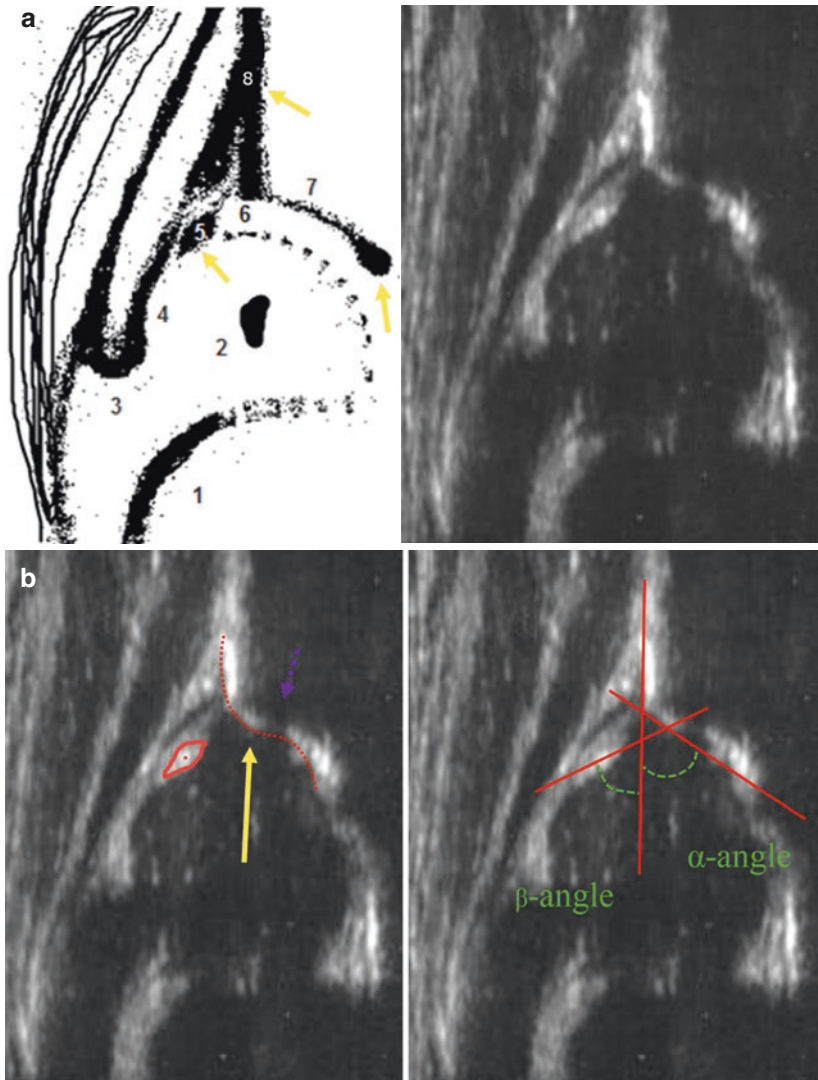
Hip types based on ultrasonographic results, according to the Graf classification. (a) Correct hip ultrasound images must fulfil certain criteria. These criteria are divided into two usability checklists: (i) the identification of 6 landmarks (numbered in the figure): (1) chondro-osseous junction, (2) femoral head, (3) synovial fold, (4) joint capsule, (5) labrum, (6) cartilagenous part of the acetabular roof, (7) bony roof, and (8) the plane (i.e. ilium, which must look like a straight line); (ii) the identification of three landmarks (marked with yellow arrows) are essential to establish the standard plane which is required for accurate measurement of infant hip ultrasound: the lower limb of the bony roof (usually it is the brightest and largest lower end of the bony roof), and the midportions of both the Ilium and the labrum. If any of these points are missing or not clearly shown, the sonogram is worthless and should not be used. The only exception is when the joint is decentered (dislocated) (Graf IV). (b) When ultrasound images are accepted based on the criteria mentioned above, the angles can be accurately measured. It is important
